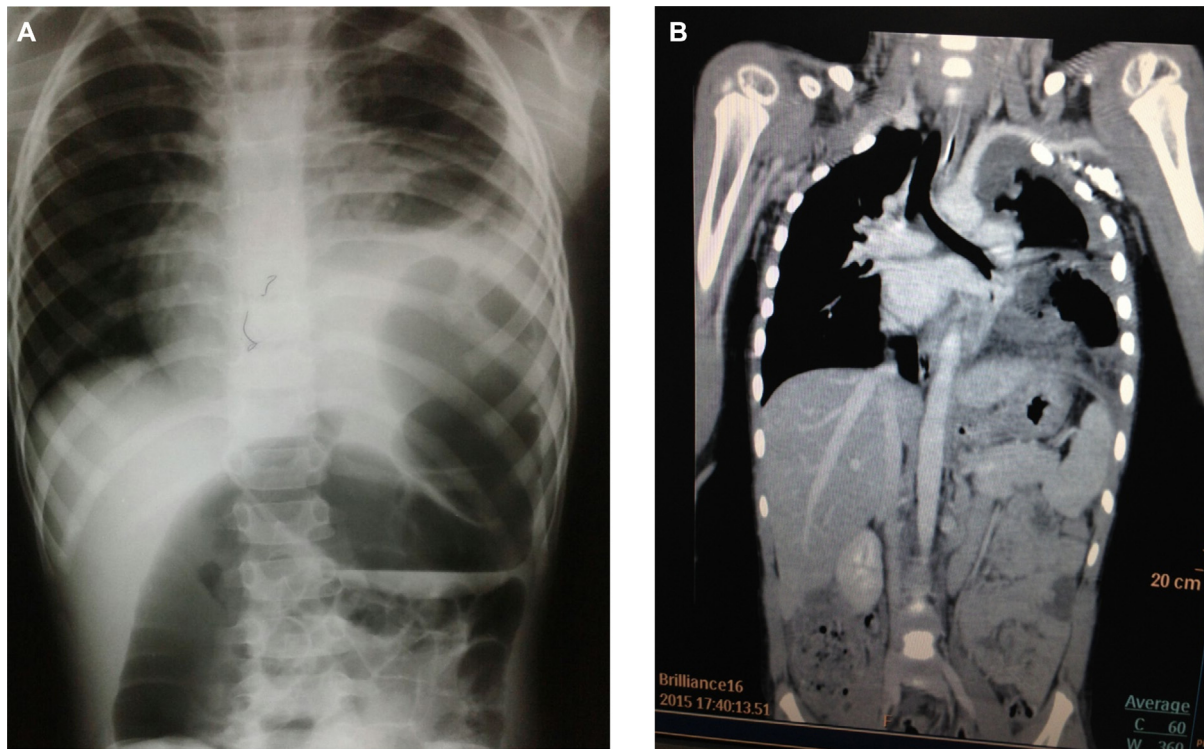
(A and B) Raised left hemidiaphragm with abdominal contents inside left hemithorax with mediastinal shift to right (radiograph and Computed Tomography (CT) respectively of chest and abdomen).
